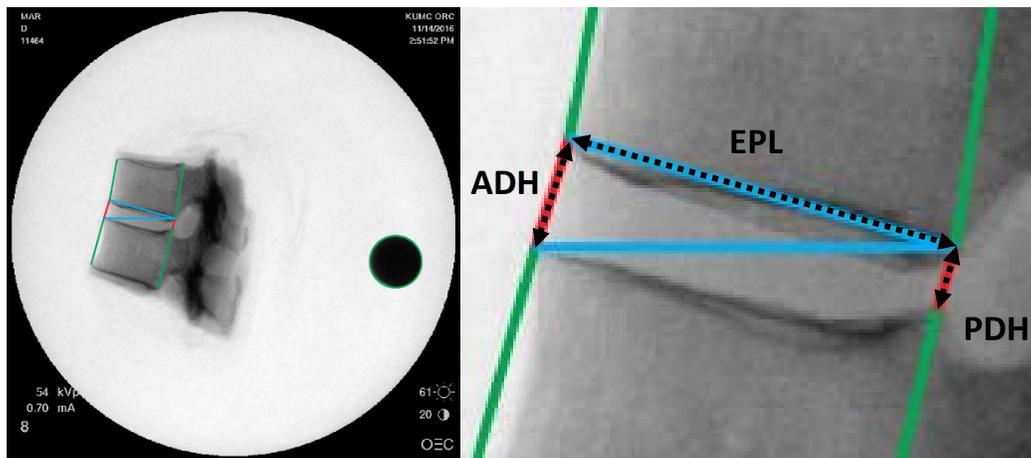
Example radiograph (left) of a dissected T11-T12 functional spinal unit showing geometric measurements (right) which included: anterior and posterior disc heights (ADH and PDH respectively), T11 end plate length (EPL), and the diagonal line from the posterior edge of the inferior endplate of T11 and the inferior edge of the anterior disc height line. A coin was used for length calibration (green circle in left image).
